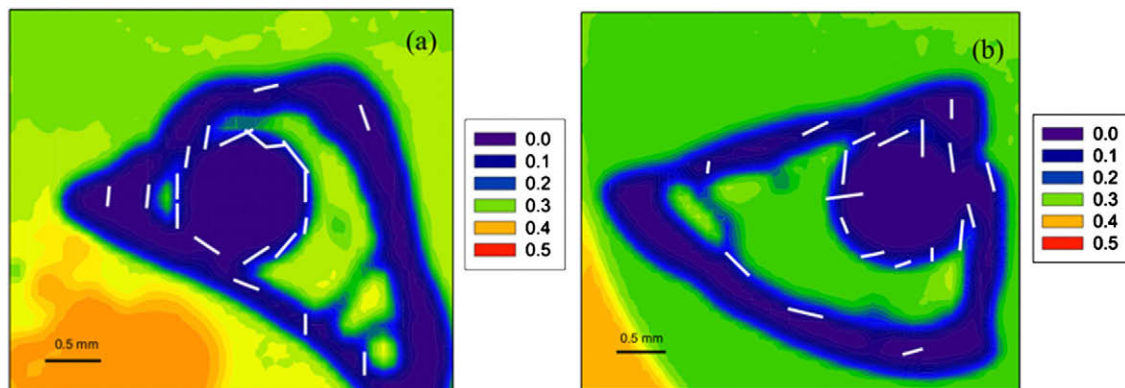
Radiograph of the samples (a) C10 and (b) C30 samples after 60 days of implantation measured with SAXS showing the intensity of the transmitted X-ray through the sample section. The small white bars denote the degree of orientation of the mineral particles in the measured spots around the implant, the size of bar denotes the degree of alignment and the direction of the bars denotes the orientation of the mineral particles. It can be noted that the white bars are oriented along the implant surface in newly formed bone in C10 sample (a) and randomly distributed in C30 sample (b).
